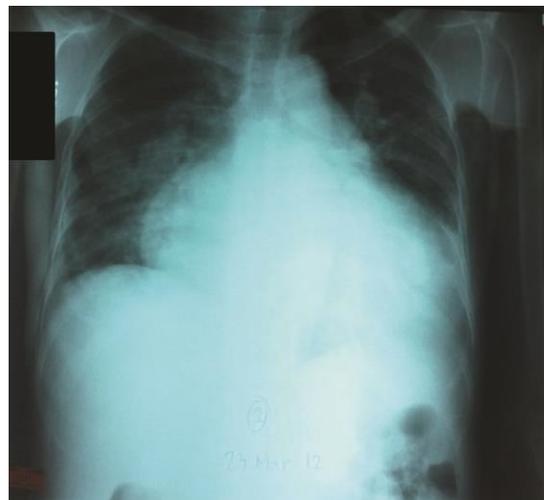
Chest x-ray showing cardiomegaly (Cardiothoracic ratio of 0.74) with evidence of pulmonary congestive changes.
